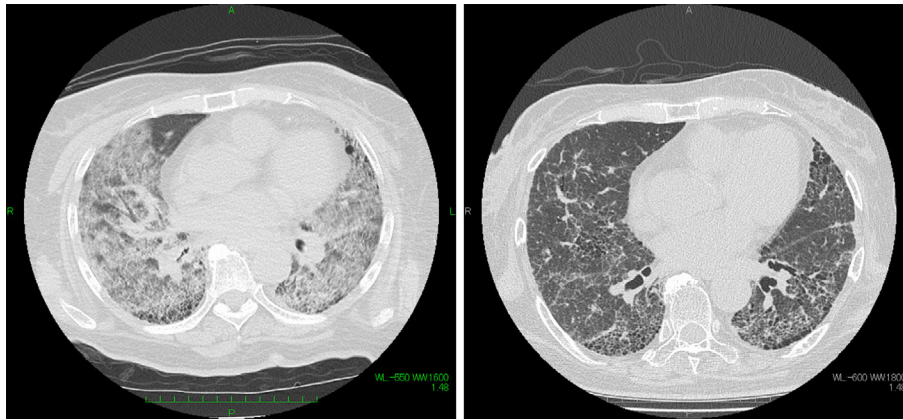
Chest computed tomography. Chest computed tomography on the sudden onset of dyspnea showed broad infiltrative shadows and ground glass opacity in the lungs (left panel). Diffuse alveolar hemorrhaging and acute deterioration of interstitial pulmonary fibrosis was diagnosed. The therapy with plasma exchange and low-dose prednisolone was dramatically effective, and these shadows were considerably attenuated after one month (right panel).
